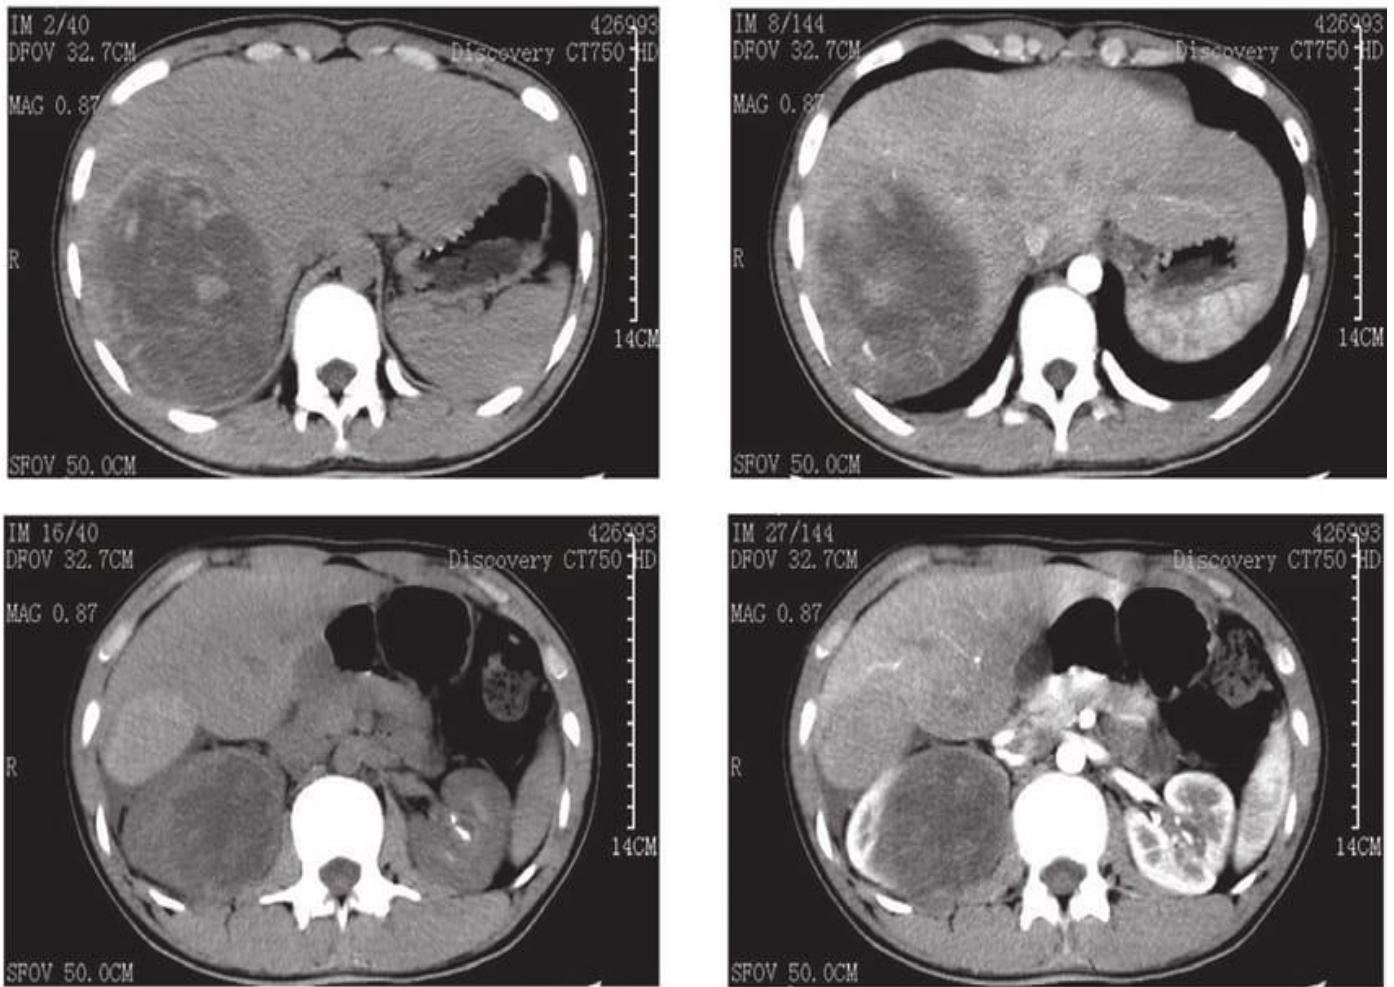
Multislice CT of the abdomen and pelvis showed the right kidney with large heterogeneous solid mass in its upper pole measuring 60 x 55 mm with focal bulging of the capsule to renal pelvis with heterogenous contrast enhancement.
